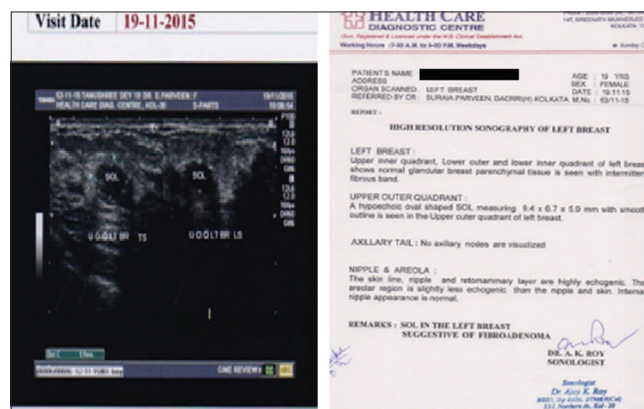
Ultrasonography report of the left breast on November 19, 2015 (longitudinal sections and transverse sections), after treatment
